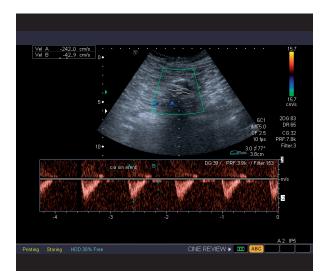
Patient DUS and CT image in post-EVAR follow up with graft stenosis detected (242 cm/s in DUS equal to approximately 60% stenosis)
